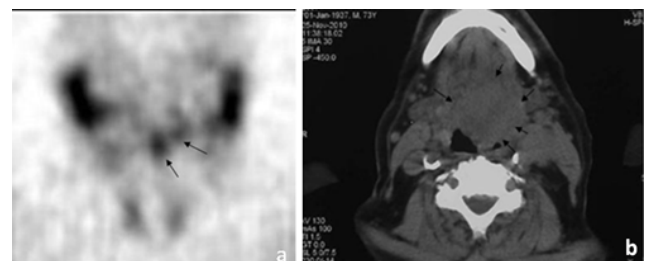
Patient No. 4 with base of tongue cancer: (a) SPECT coronal slice (arrows showing the ^{99m}Tc -TF uptake); (b) relevant CT slice (arrows showing the tumor)
